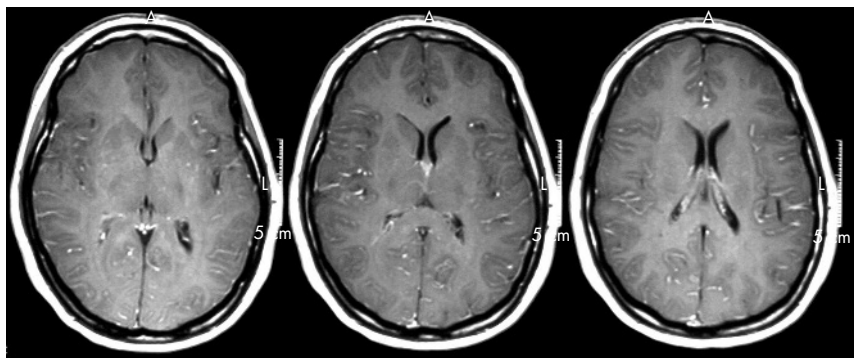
Cranial MRI: T1 sequences with gadolinium contrast showing subtle but widespread cerebral leptomeningeal enhancement without thickening or nodularity.
